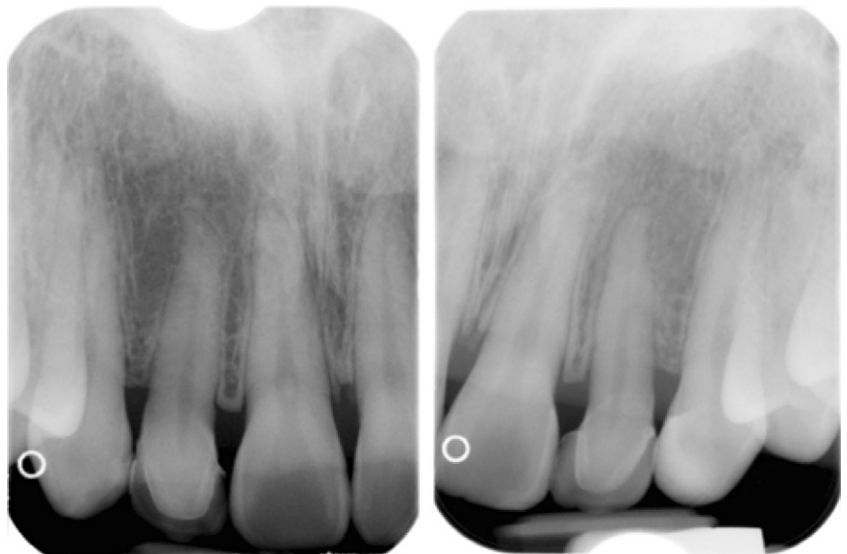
Radiographs were taken to ensure non-overlapping restorations.
